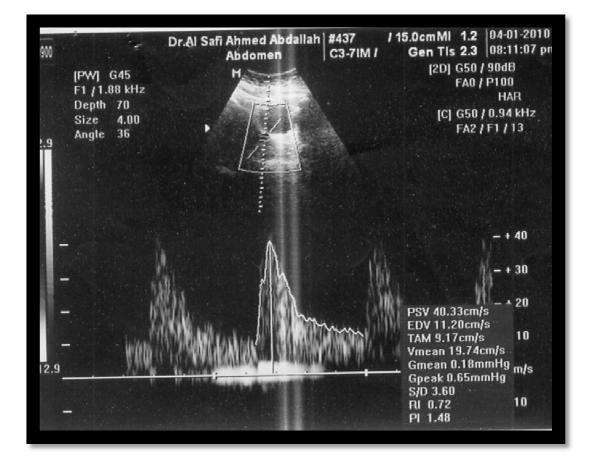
21 patient has a history of (RPL) color Doppler abdominal scan showing complete abortion.
